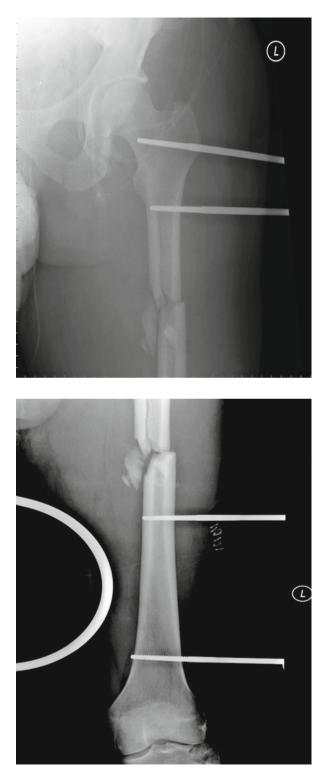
Radiograph of external fixator pins in proximal femur
